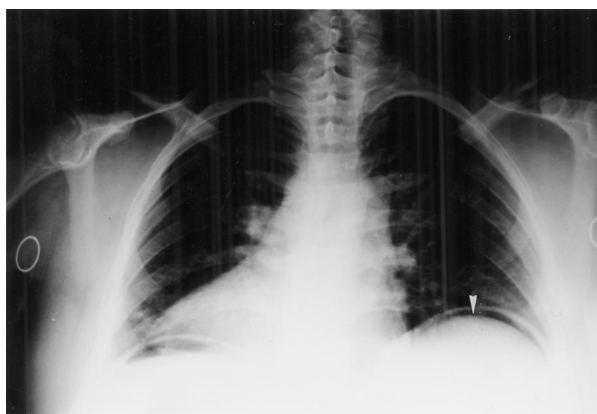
Plain film of chest showed the free air in the bilateral subdiaphragmatic area (arrow head).
